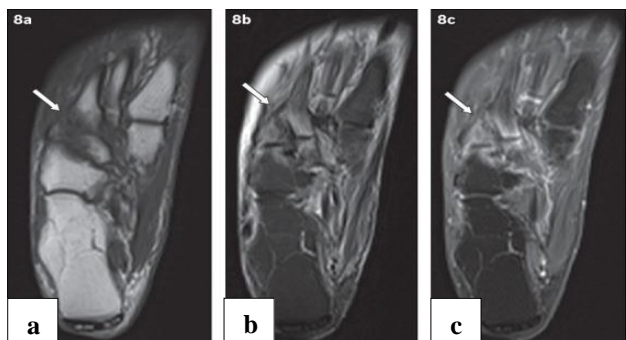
An 81-year-old woman presented with tenderness over the dorsum of the right foot, with associated inflammatory skin changes. Axial (a) T1-W, (b) T2-W FS and (c) contrast-enhanced T1-W FS MR images of the right foot show periarticular high T2-W signal with corresponding enhancement, centred on the tarsometatarsal joints (arrows). The typical location, coupled with the absence of other secondary soft tissue signs of infection (e.g. ulcer, cellulitis, abscess, sinus tract), indicated the diagnosis of acute neuroarthropathy.
